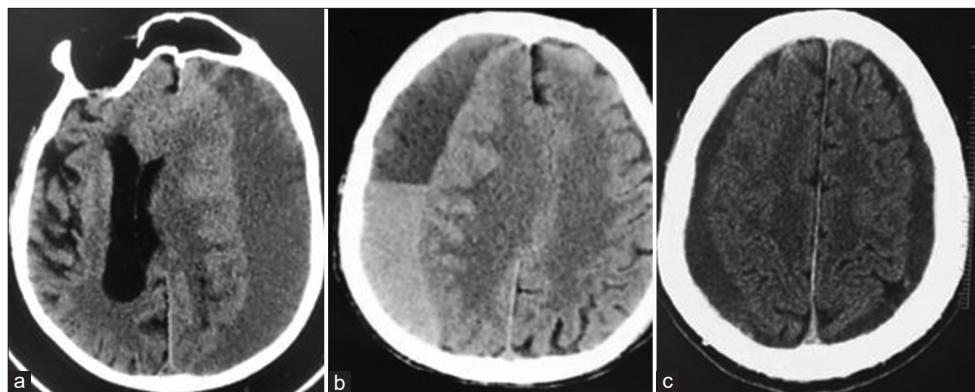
Axial cuts of cranial computed tomography scans showing different stages of chronic subdural hematomas (cSDHs). (a): Left hypodense cSDH, (b): Right laminar cSDH, (c): Bilateral hygroma. Courtesy of ZHUMC radiology department, Jnah, Beirut, Lebanon.
